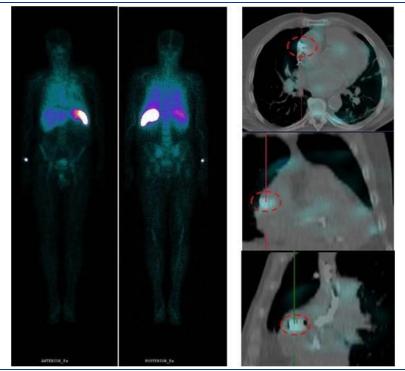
Labelled WBC scintigraphy. Whole Body images taken 30 minutes after labeled [^{99m}Tc]Tc-HMPAO WBC administration, anterior and posterior projections. The spleen, liver, and red bone marrow are visualized on the images, in accordance with the physiological distribution of the labelled WBC (left). SPECT/CT images in axial, frontal and sagittal views (up down), taken 4 hours after labelled [^{99m}Tc]Tc-HMPAO WBC administration. Low-intensity focal hyperfixation of the labelled WBC in the right atrial electrode site (highlighted in red) is visualized in the images (right)
